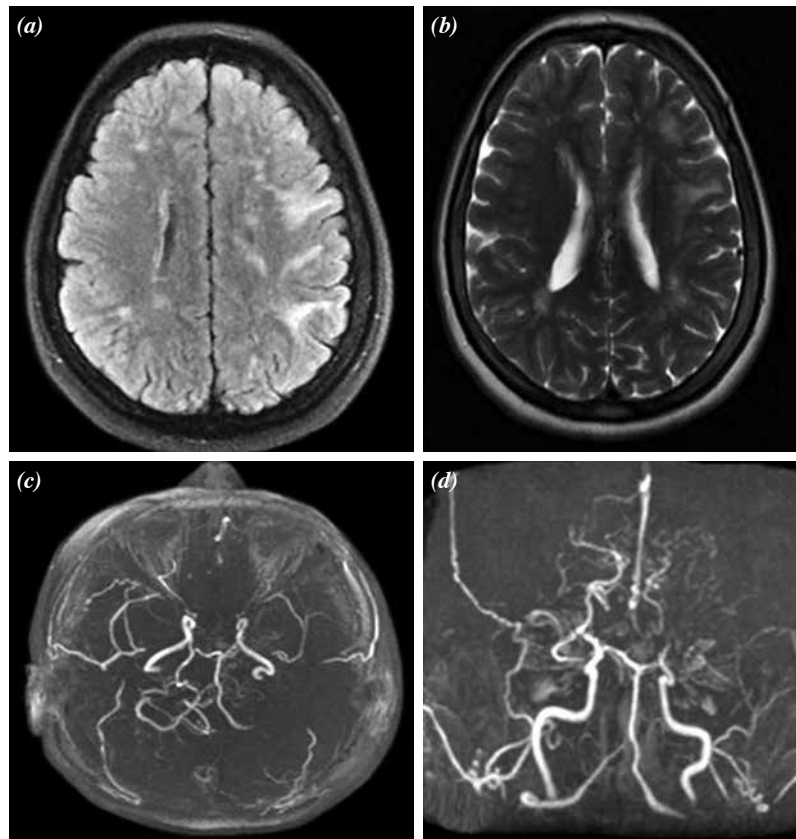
(a, b) In brain magnetic resonance imaging flair and T2 axial sections, hyperintense lesions are noted, prominent on left. (c, d) Brain magnetic resonance angiography shows that major vessels are not adequately observed as from distal of internal carotid artery.
